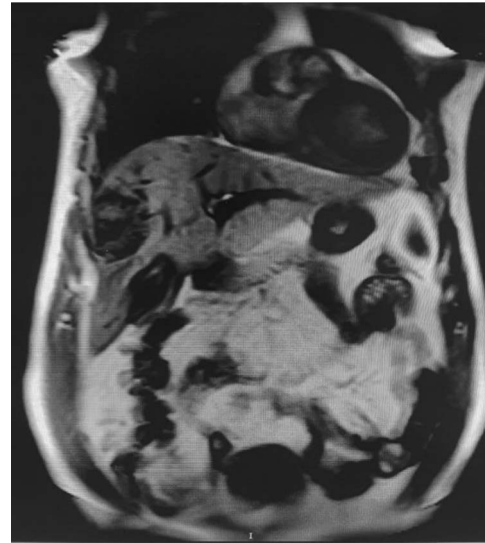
MRI of the abdomen with tumorous alteration of S5/S8 liver segments and infiltration of the anterior branch of the right portal vein.
